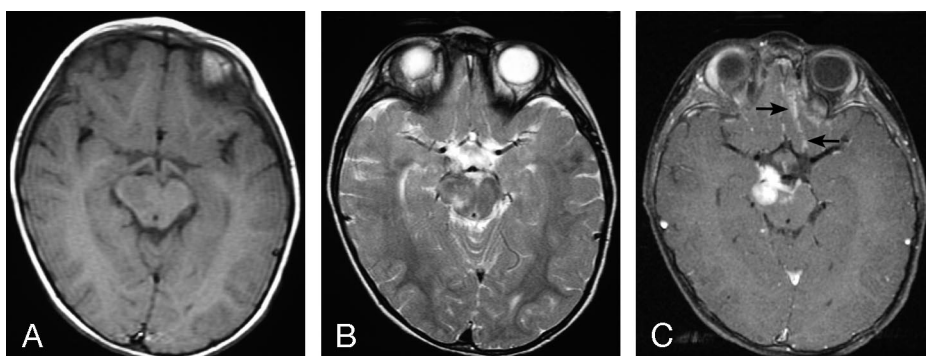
MR images of a 1.3-year-old boy with AT/RT in the right cerebral peduncle.
